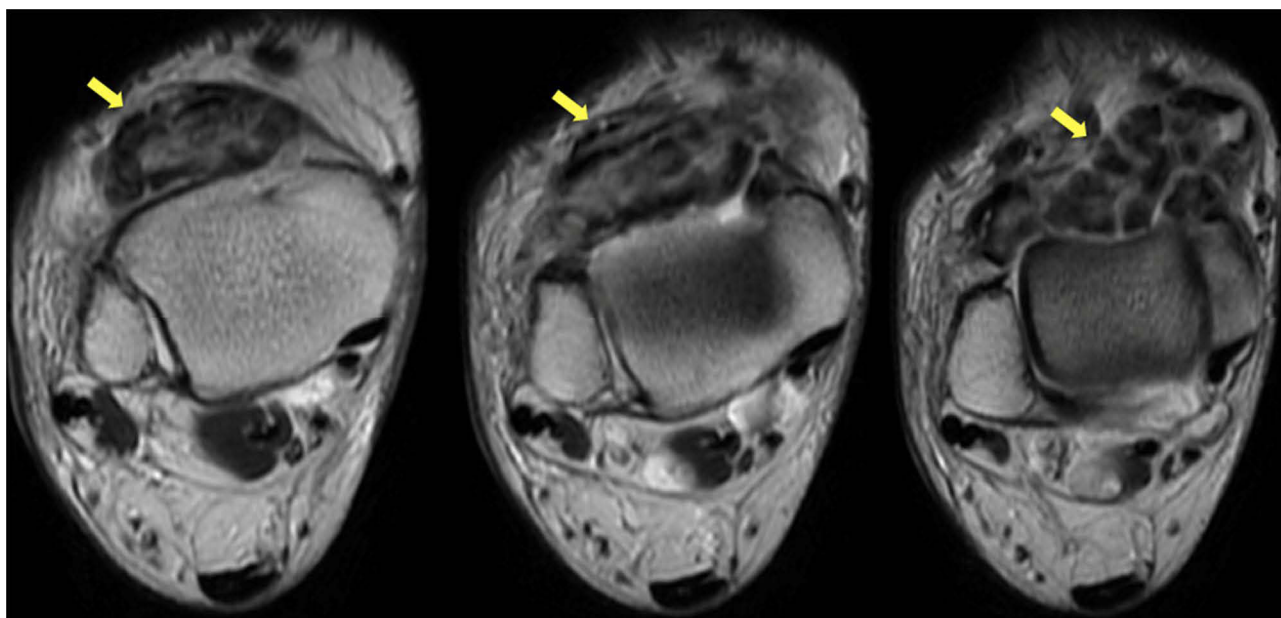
Axial MRI T2 of the right ankle showing anterior calcified loose bodies specified by the yellow arrows.
